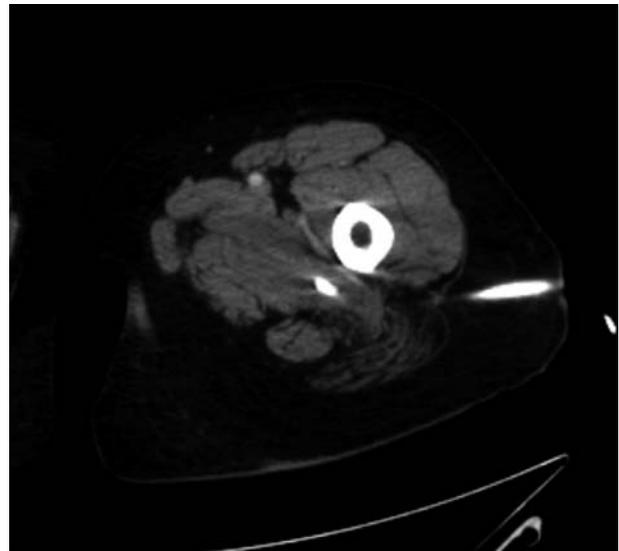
CE-CT, after 8 days with drainage.
